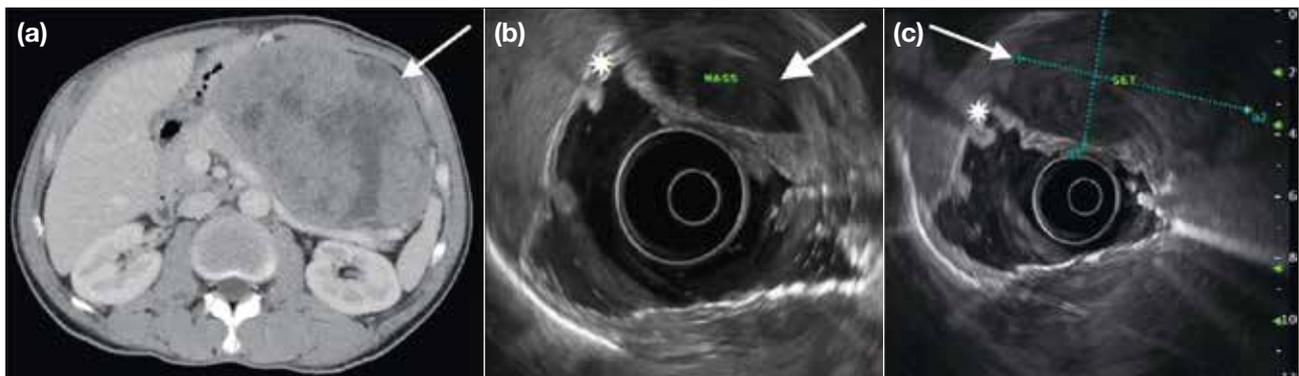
Gastric gastrointestinal stromal tumour in a 53-year-old man. (a) Contrast-enhanced computed tomography showing a heterogeneously enhancing mass arising from the gastric body (arrow) with extension into the lesser sac. (b, c) On endoscopic ultrasound, the tumour (arrow) arises from the muscularis propria (asterisk).
